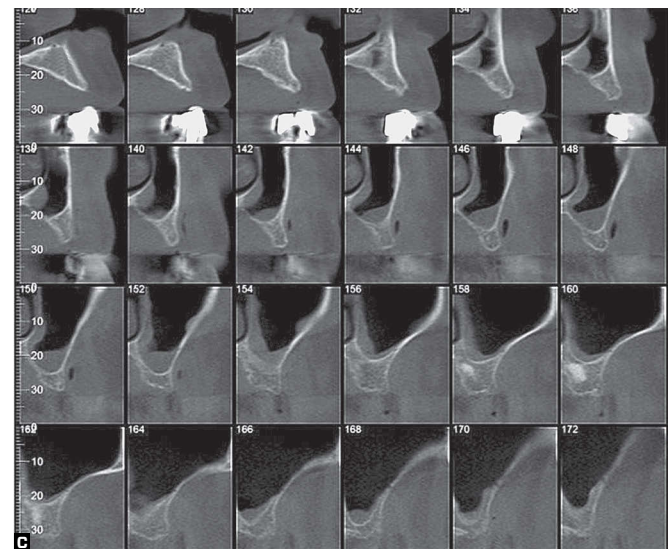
Cone-beam CT- panoramic (A) and transverse (B, C) slices.
